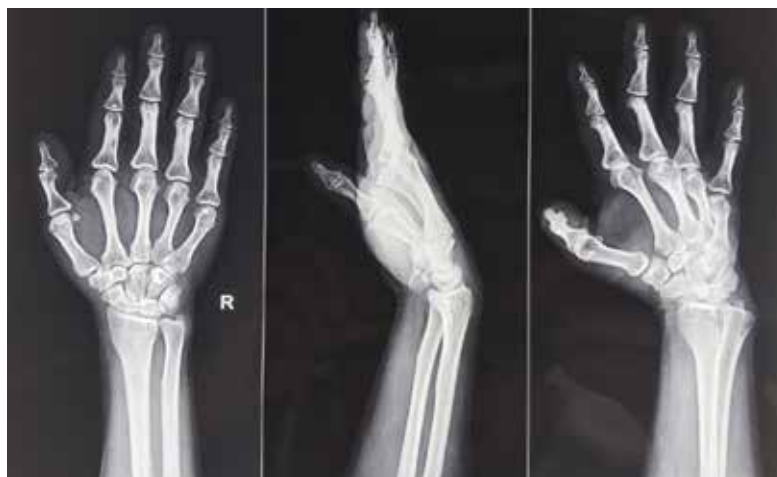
Radiographs of the right upper limb without any pathology
